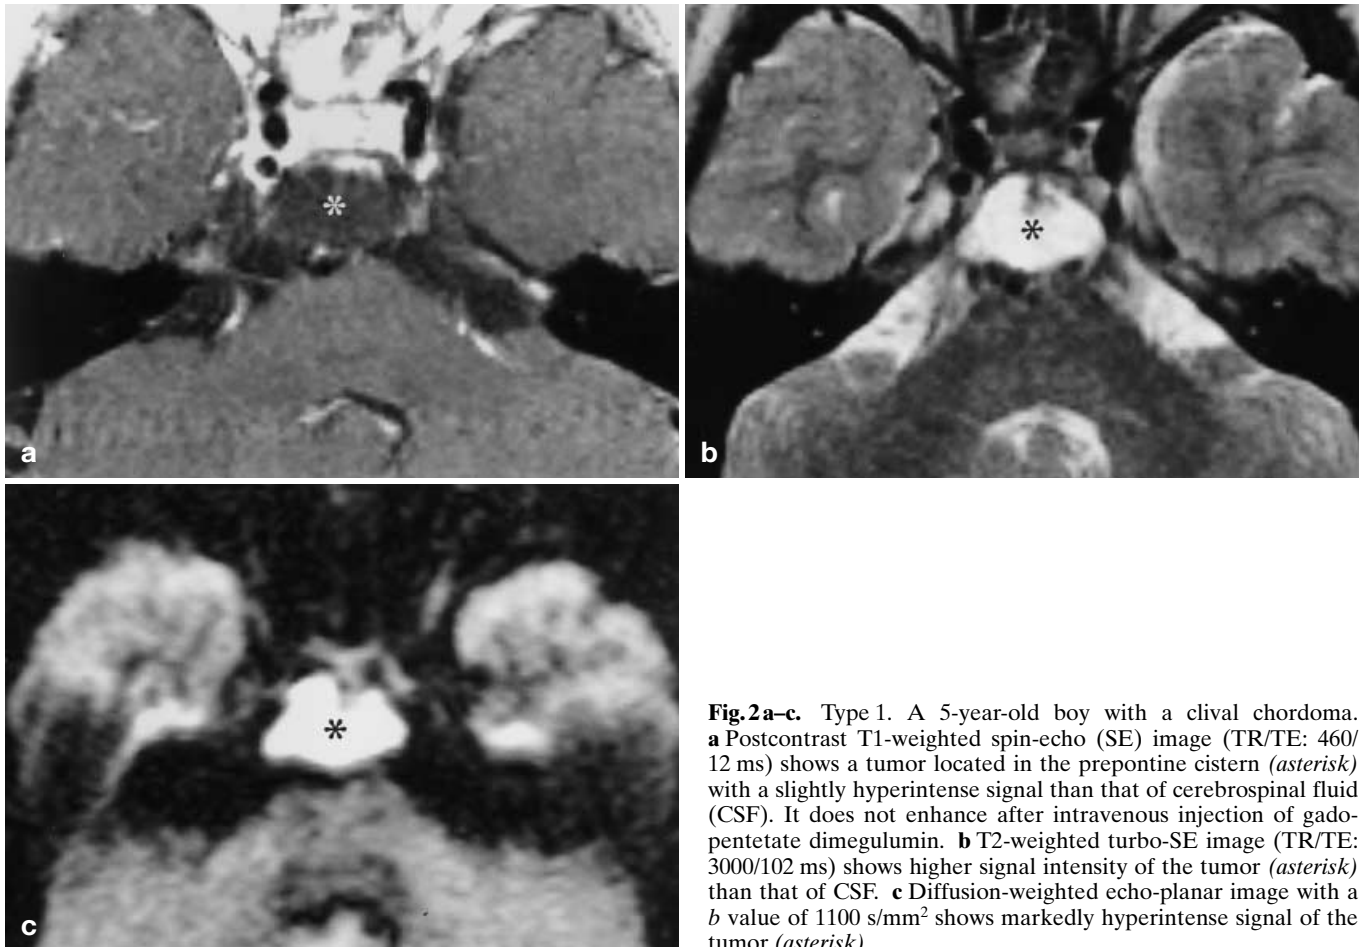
Type 1. A 5-year-old boy with a clival chordoma. a Postcontrast T1-weighted spin-echo (SE) image (TR/TE: 460/12 ms) shows a tumor located in the prepontine cistern (asterisk) with a slightly hyperintense signal than that of cerebrospinal fluid (CSF). It does not enhance after intravenous injection of gadopentetate dimeglumine. b T2-weighted turbo-SE image (TR/TE: 3000/102 ms) shows higher signal intensity of the tumor (asterisk) than that of CSF. c Diffusion-weighted echo-planar image with a b value of 1100 s/mm^2 shows markedly hyperintense signal of the tumor (asterisk)
